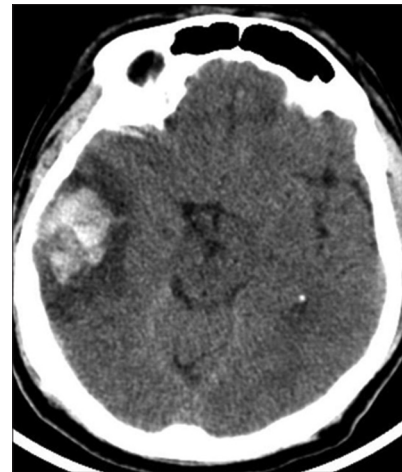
Patient randomized to conservative management presented after 3 h of injury. Glasgow Coma Scale was E3M6V4, computed tomography brain shows right temporal hematoma
